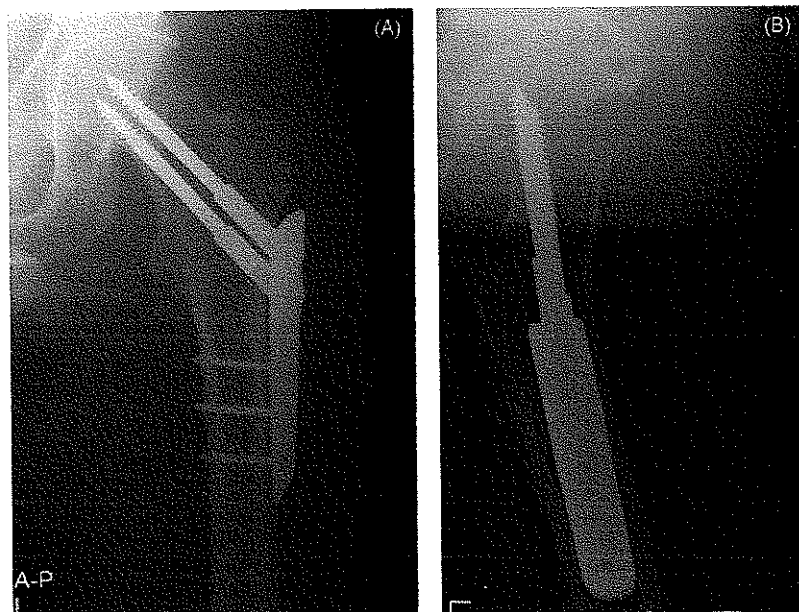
Postoperative X-ray with PCCP. (A) AP view and (B) lateral view.
